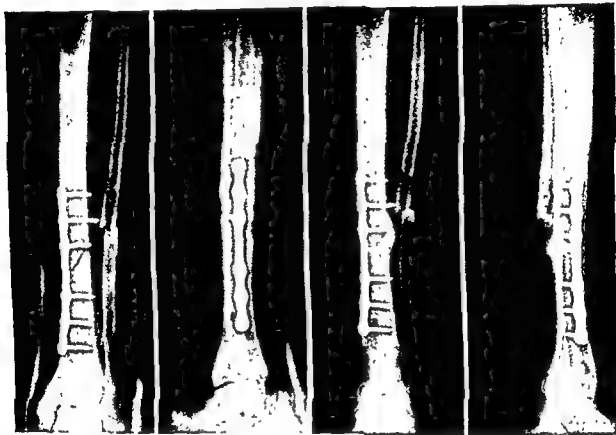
X-rays of fracture of tibia and fibula immediately after plating and three months later, showing clinical union.
